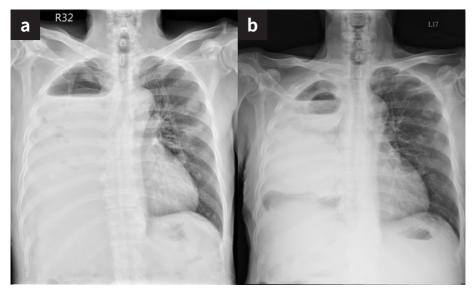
Chest radiography at lung cancer diagnosis Figure 1b: Chest radiography after three cycles of nivolumab Abdominal radiography showed no dilated bowel gas (Figure 2). Laboratory data showed that hemogram, biochemistry, and electrolytes were all within normal limits.
